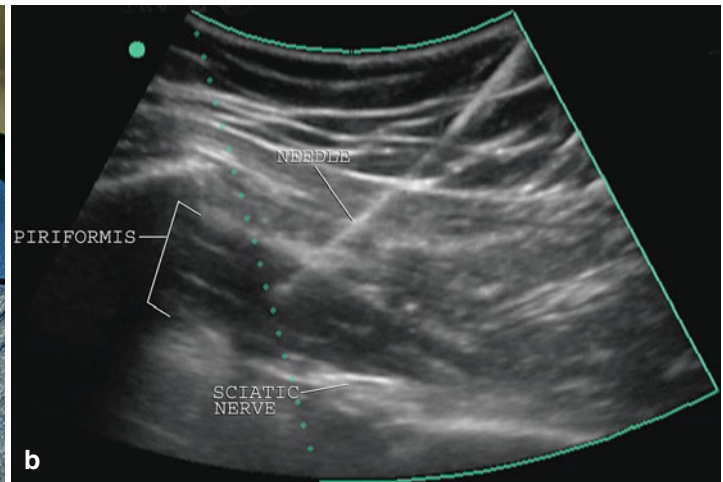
(a) The needle is inserted into the musculature of the piriformis avoiding the sciatic nerve. (b) The ultrasound image shows the needle entering the piriformis a safe distance from the sciatic nerve. (All rights are retained by Dr. Byrd)
